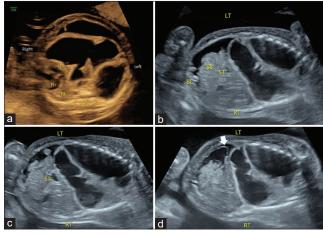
(a) Sonographic image of the transverse section of the thorax at the level of the heart showing a cystic lesion occupying most of the thorax causing extreme dextroposition of the heart, (b) coronal view of the fetus showing ascites, subcutaneous edema, and cystic lesion. Furthermore, diaphragmatic continuity is not maintained, (c) coronal view demonstrating intraabdominal stomach, (d) section showing ascites with an intact diaphragm (arrow). FH: Fetal Heart, LL: Left Lung, RL: Right Lung, Sp: Spine, ST: Stomach, SB: Small Bowel, BL: Bladder, LT: Left, and RT: Right
